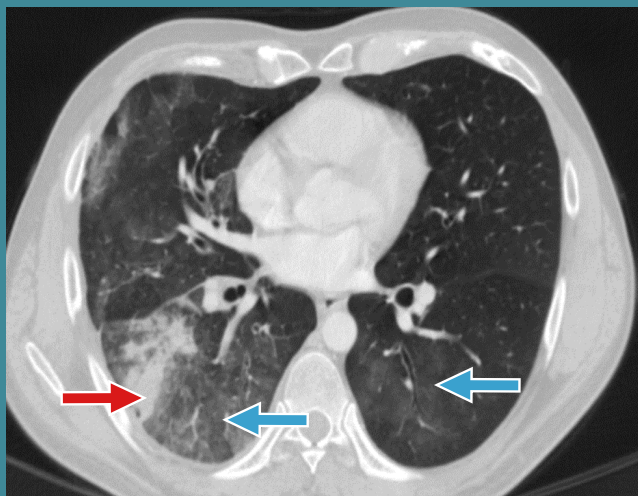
Chest CT scan with contrast (December 2018) - Regression in intensity and size of the consolidation process in RLL (red arrow), respectively ground-glass opacity (GGO) in RLL and left lower lobe (LLL) (blue arrow)
